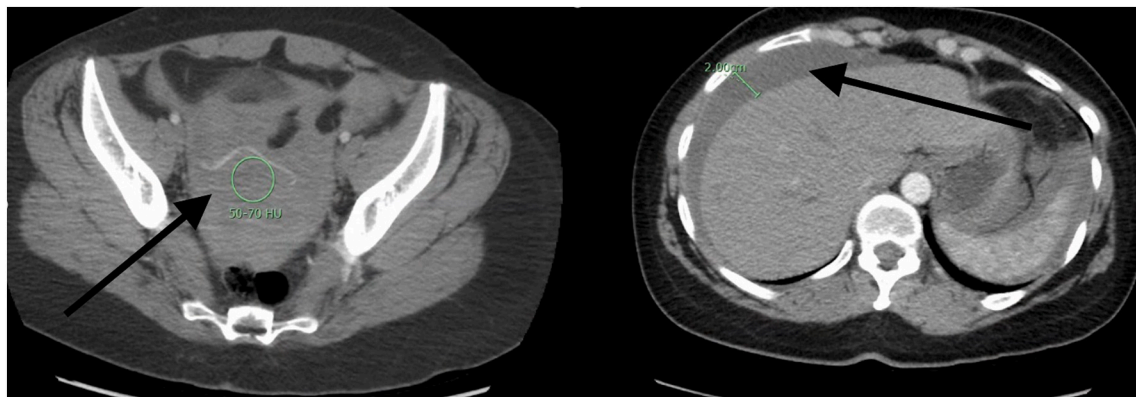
Computed tomography (CT) demonstrating hemoperitoneum. The first arrow indicates suprapubic free fluid and the arrow on the right points to peri-hepatic free fluid.
